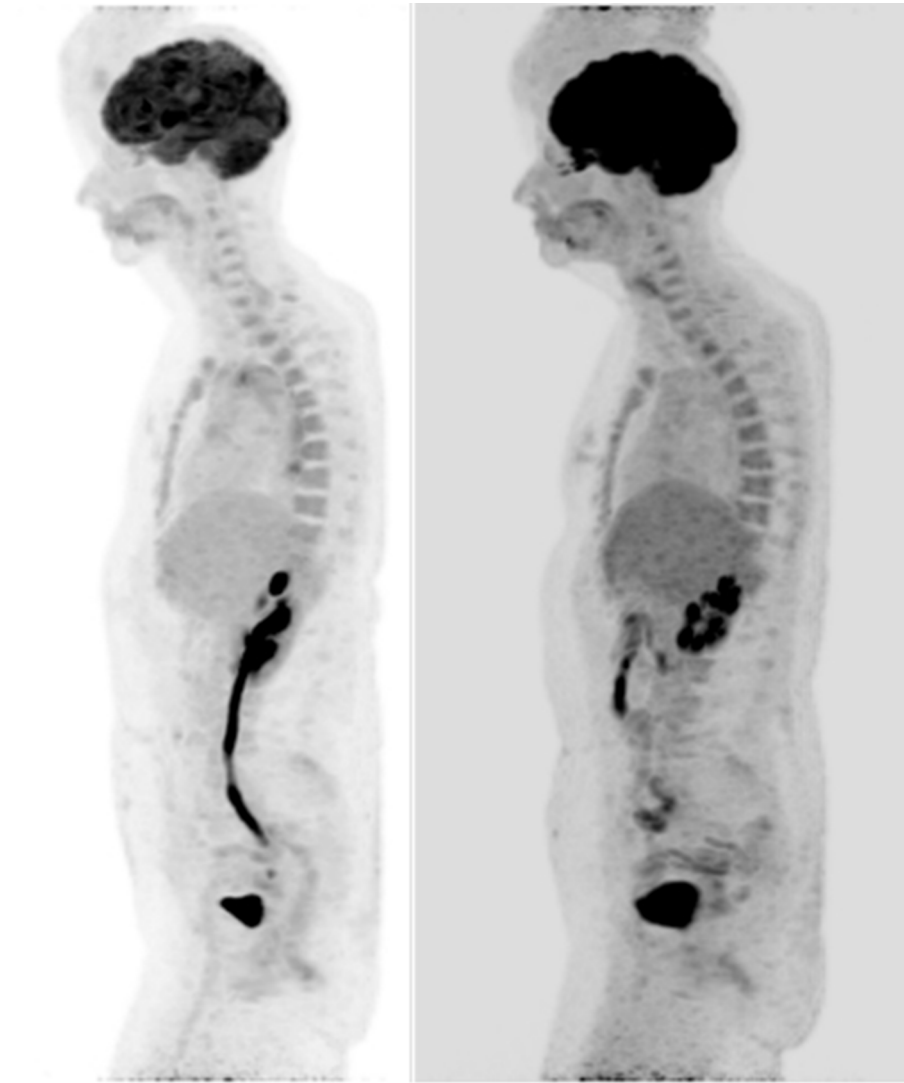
(Left image) MIP sagittal ^{18}F -FDG PET-CT shows increased FDG avidity in the aortic wall corresponding to the mural thickening. (Right image) Post therapy MIP Sagittal ^{18}F -FDG PET-CT shows complete resolution of the abnormal metabolic activity in keeping with a metabolic response. MIP, maximum intensity projection.
